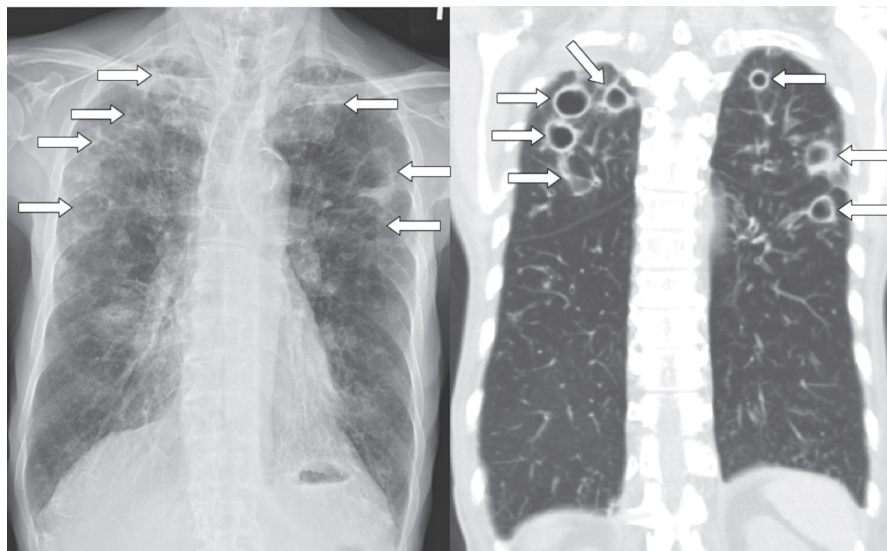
Culture-proven pulmonary tuberculosis in an 88-year-old man, who had a history of diabetes mellitus and a glycosylated hemoglobin (HbA1c) level of 10.7% at the time of tuberculosis diagnosis. Chest radiograph (A) and coronal thoracic CT image (B) show multiple cavitary lesions (arrows) in bilateral lungs.
